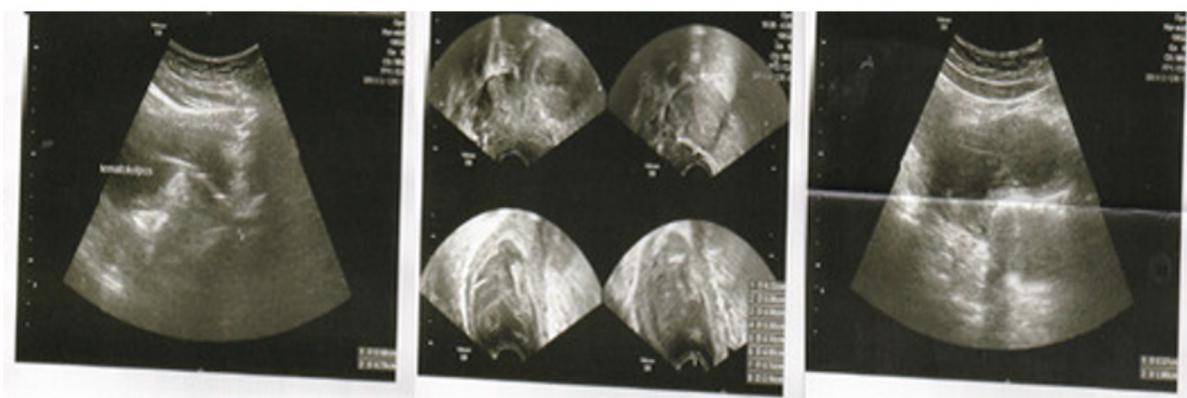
Trans abdominal ultrasonography (didelphys uterus, left hemiuterus with hematometra, right hemiuterus without hematometra)
